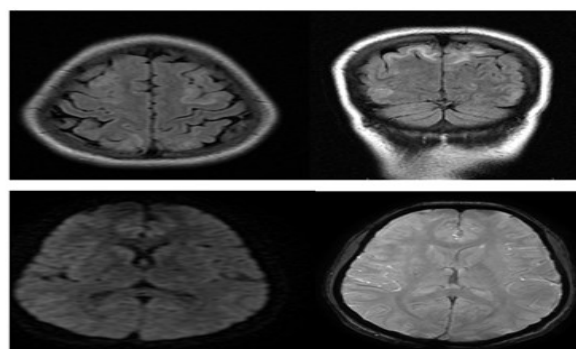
30 years old female with h/o seizures on post-partum 7th day. Axial/Coronal T2 FLAIR, DWI and SWAN reveals symmetrical FLAIR hyperintense signals involving cortical and subcortical areas in the bilateral parietal region with no restricted diffusion-Suggestive of PRES
